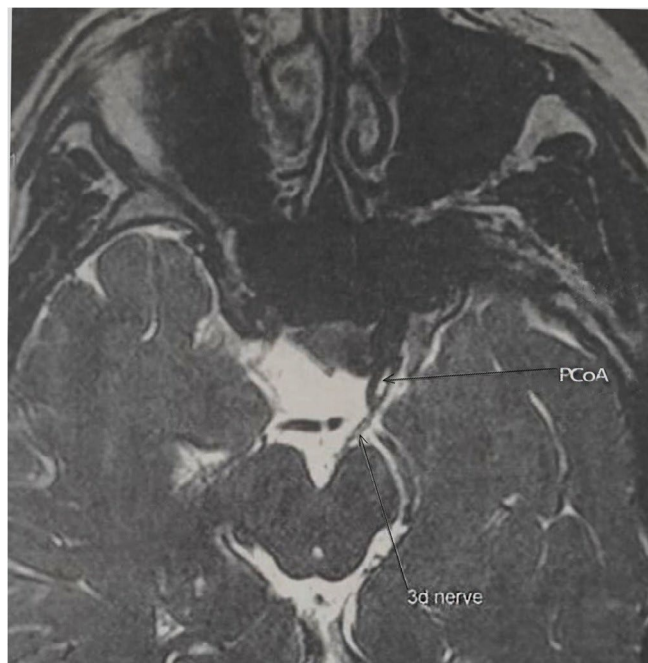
Oculomotor nerve trajectory. MRI FIESTA sequence showing normal size and shape of the nerve at the site in which the oculomotor nerve exits from the midbrain and also a normal pathway of the nerve inside the interpeduncular space toward cavernous sinus. 3d nerve, third cranial nerve; PCoA, posterior communicating artery
